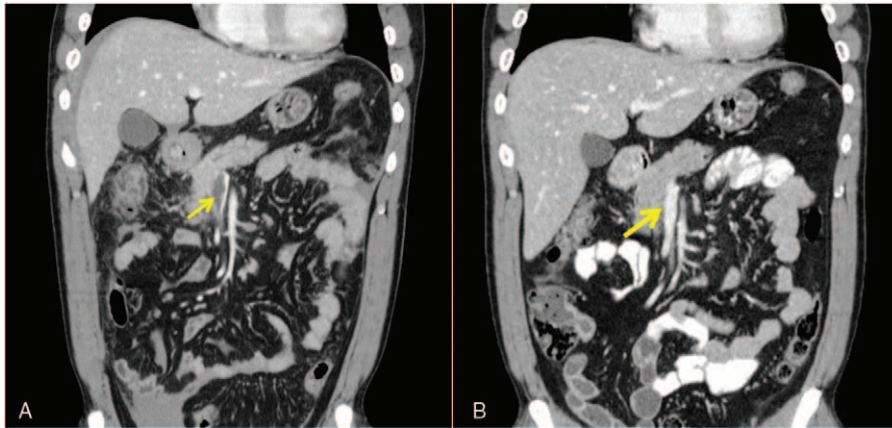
CT scans of patient 1 (A) 1 week after admission and (B) after 1 month of anticoagulation.
